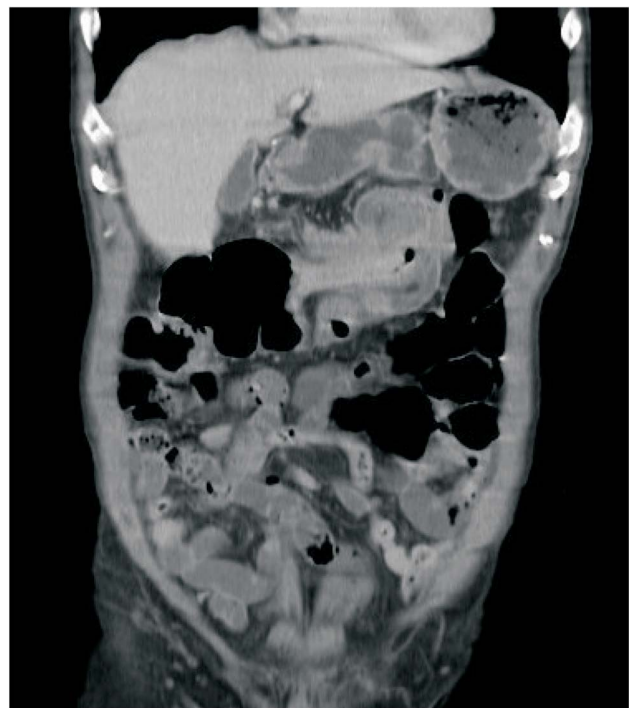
The computed tomography showed intussusception at transverse colon in patient 14.
